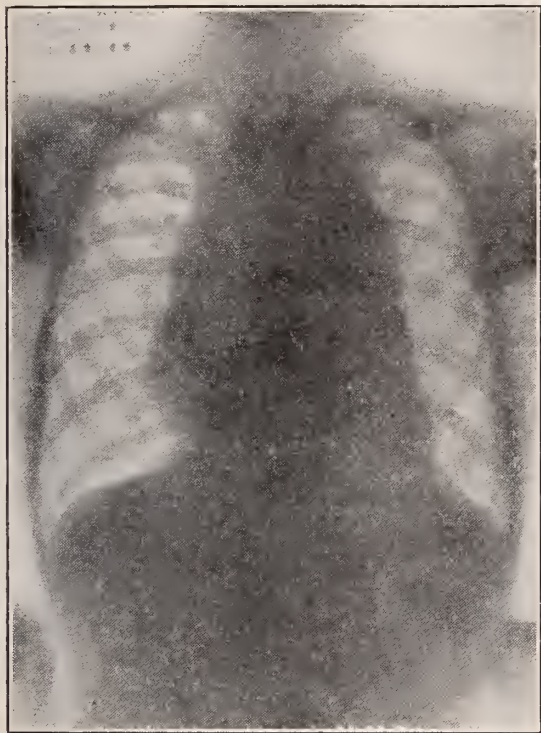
x-Ray picture of chest following treatment.
